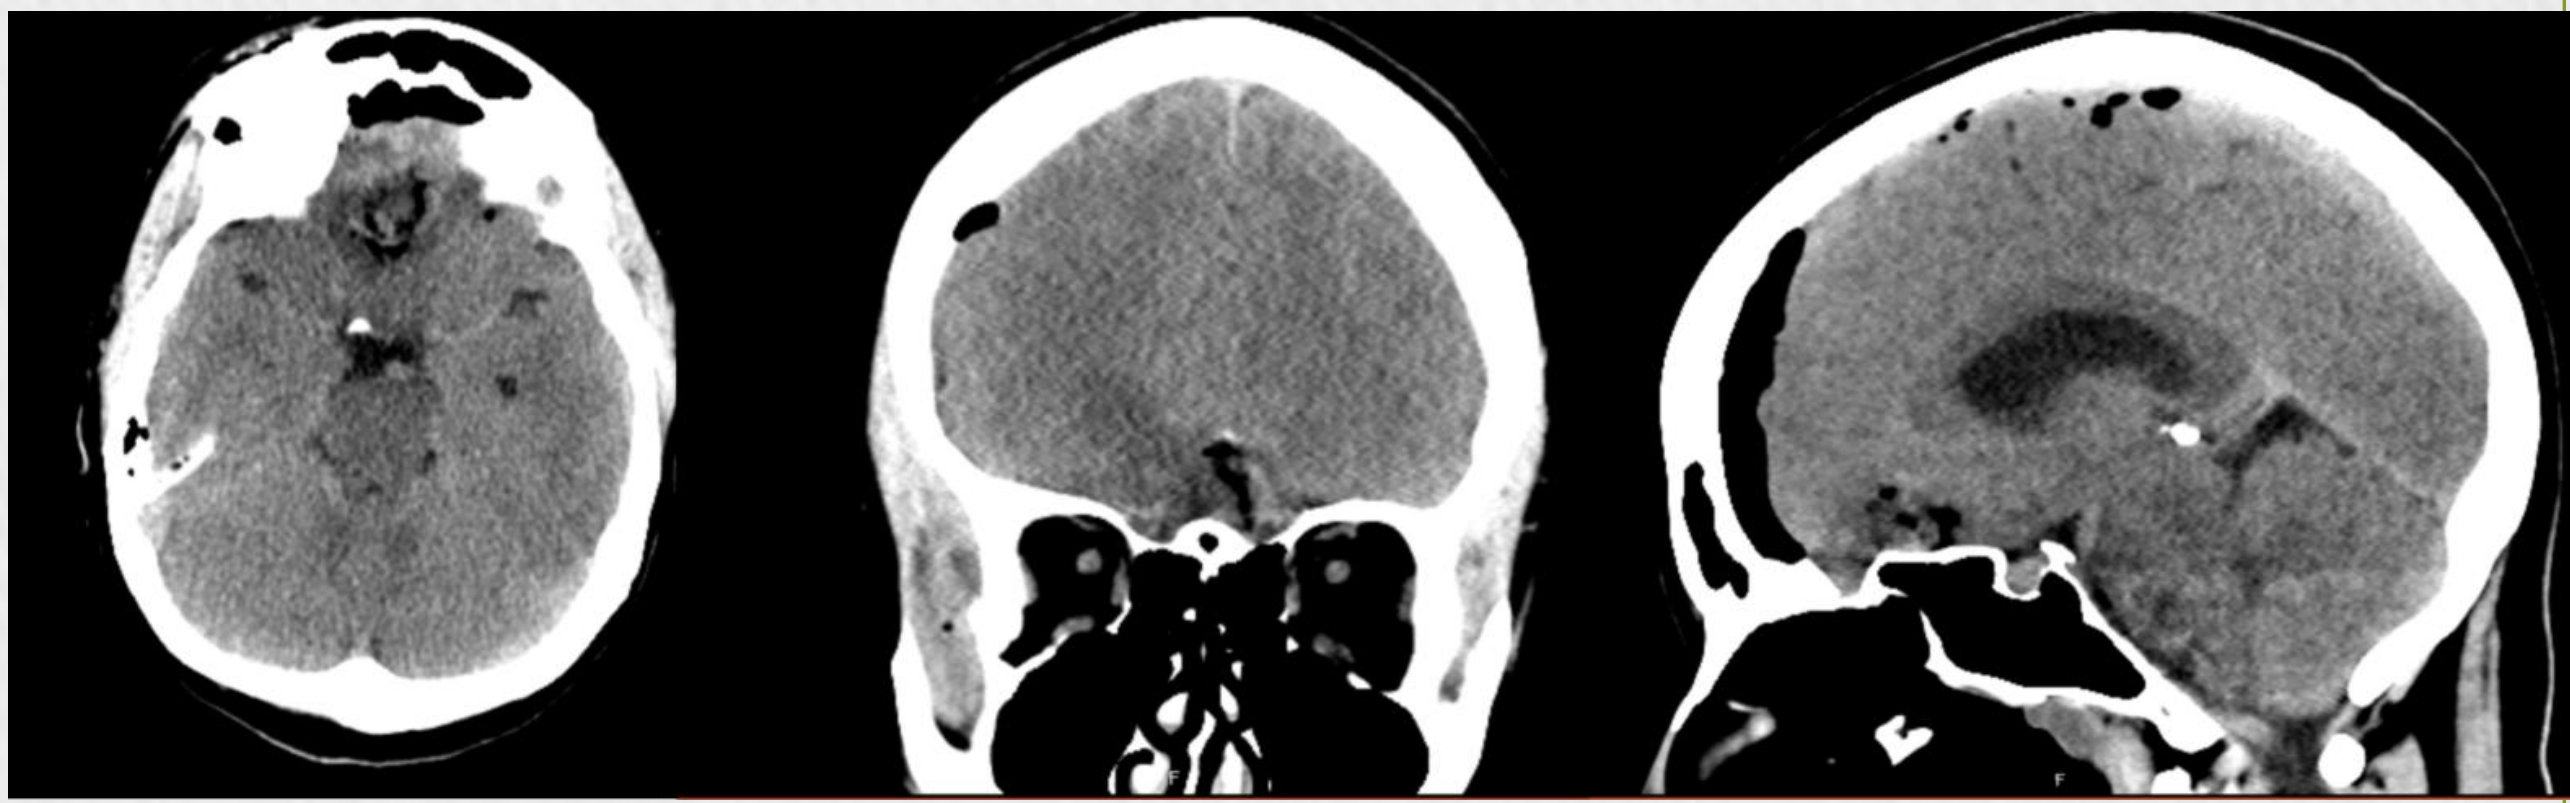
Post-operative CT head with as expected post-op changes.
